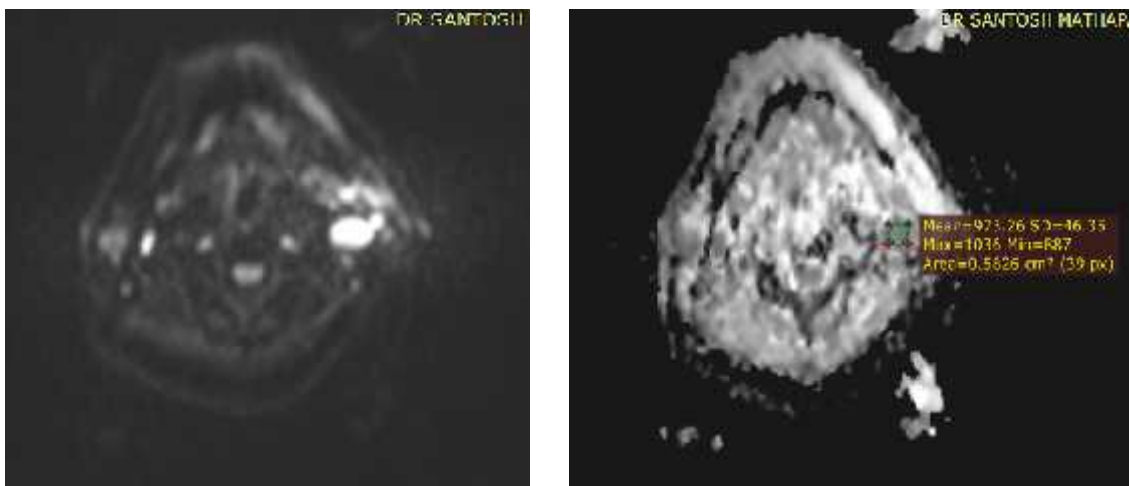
C and D: DWI (b- 800)and ADC show a subcentimetric left level II node with no diffusion restriction.
